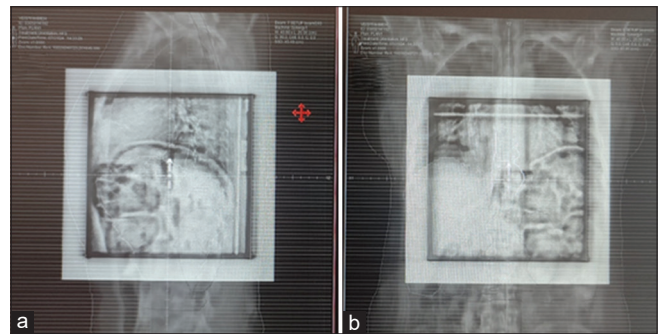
Image from the MOSAIC system obtained from treatment planning system (TPS), (a) Matched anterior to posterior digital reconstructed radiography (DRR) and portal images, (b) Matched lateral DRR and portal images. Image matching was performed by considering the bony structures
